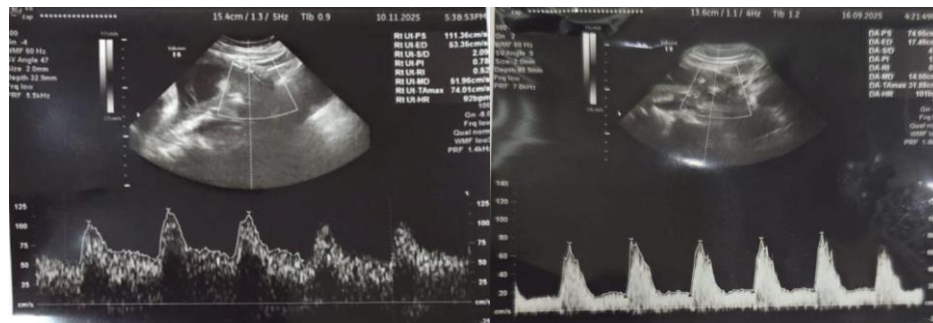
Representative images of Uterine Artery Doppler wave forms:
